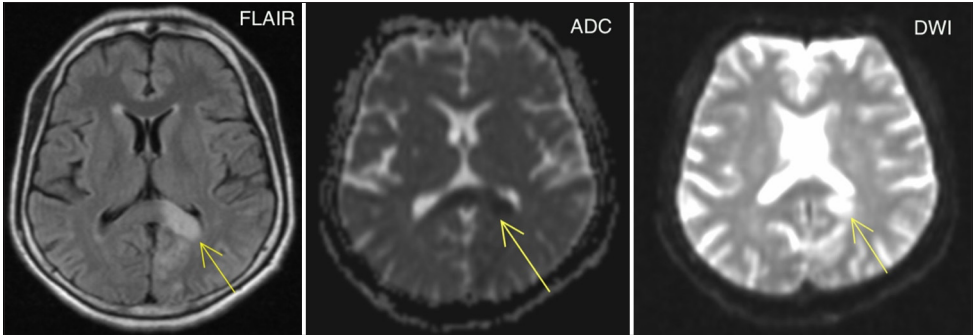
Magnetic resonance imaging sequences of the patient showing Splenium Infarction
